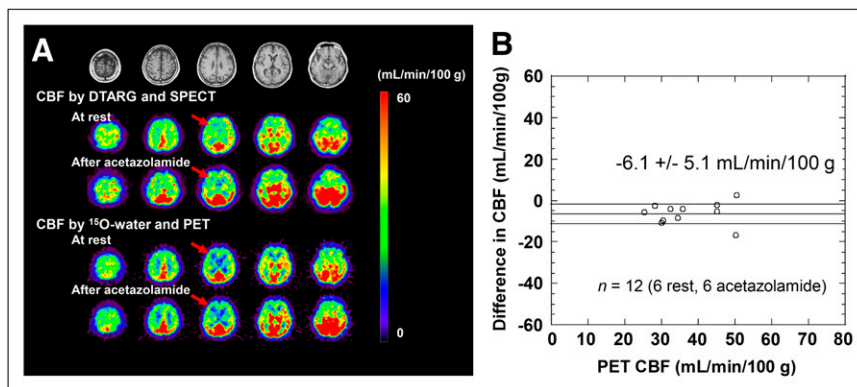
shows MR and CBF images at rest and after acetazolamine obtained with DTARG SPECT and  $^{15}\text{O}$ -water PET in a 73-y-old male patient (63 kg) with right internal carotid artery occlusion and left internal carotid stenosis. The MR images do not show any evidence of cerebral infarction in either hemisphere. Rest CBF was reduced bilaterally in the frontal-to-parietal regions, and acetazolamide increased CBF in left parietal regions but not in the right parietal area. DTARG CBF indicated the loss of vasoreactivity in the right internal carotid artery stenotic area. These findings were consistent with those from the PET evaluation. An additional example is shown in Supplemental Figure 4 for a 74-y-old female patient (48 kg) with left internal carotid artery stenosis, for whom MR images did not show cerebral infarction. DTARG CBF demonstrated preserved CBF in both hemispheres but reduced CBF reactivity in the left middle cerebral artery territory. The findings were again consistent with those
